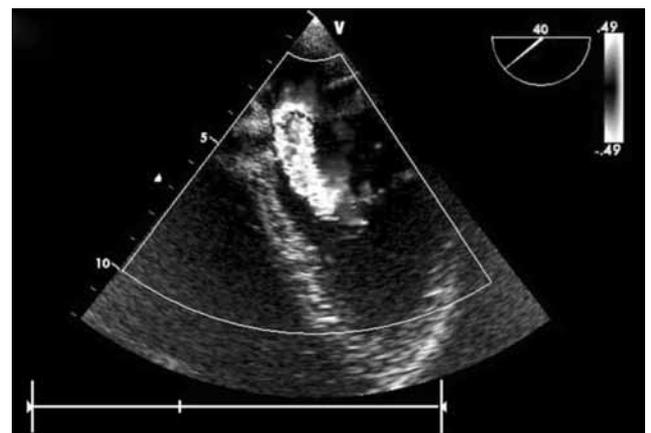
A transesophageal echocardiogram with color flow Doppler ultrasound shows a turbulent flow through an opening in the membrane near the intraatrial septum.
